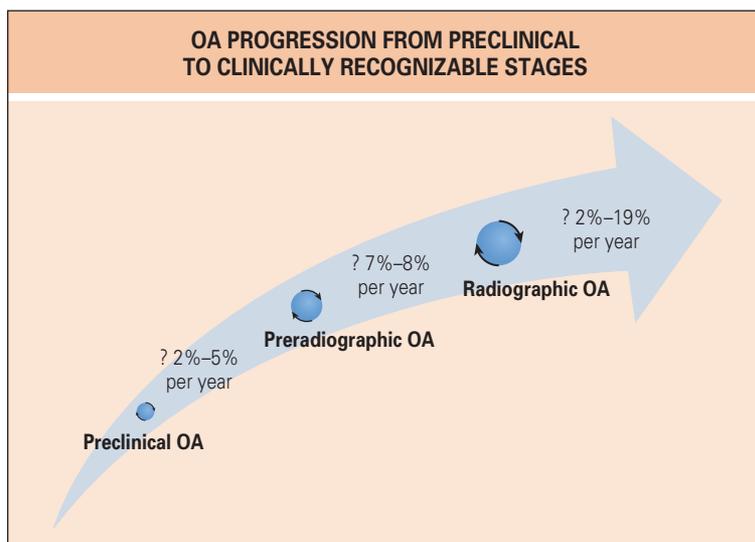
At present, the rates of evolution from preclinical to preradiographic to radiographic osteoarthritis (OA) are not precisely known. After a severe acute knee injury, the annual rate of progression in the preclinical phase of OA is at least 2% to 5% annually to account for the overall average risk of developing radiographic OA of 50% by 10 to 20 years later⁸; under less extreme circumstances, the rate is likely lower. Knowledge of rates of progression to radiographic OA from preradiographic OA are limited but may be estimated at 7% to 8% annually given the current information available.³⁷ The rate of progression of radiographic OA to more severe radiographic stages is estimated to be 2% to 19% annually based on calculations using the data from the placebo arms of a number of studies (summarized by Manno et al⁴¹ and Emrani and colleagues⁶⁵). These should be treated as rough estimates in need of refinement through future longitudinal studies with more comprehensive patient phenotyping of different joints and patient subtypes with sensitive imaging and biochemical markers.
